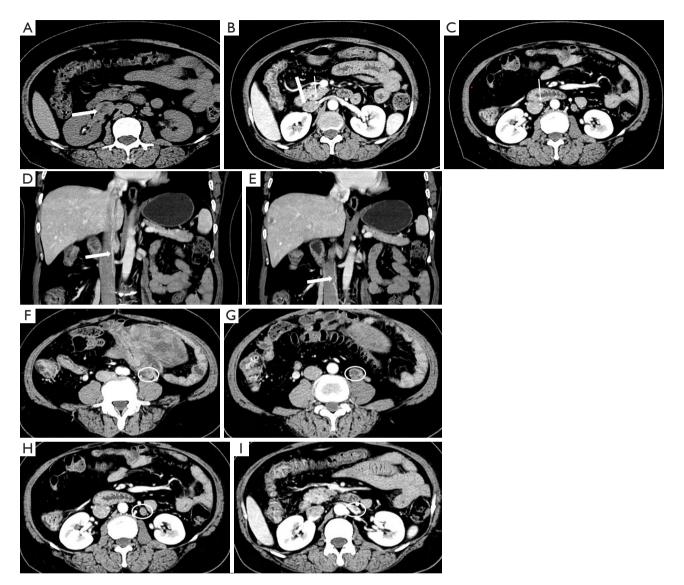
CT images. (A) The arrow points to a low-density occupying lesion within the IVC containing fat density. (B,C) Arterial phase of CT transverse section, thick arrow: IVC filling defect; thin arrow: small vessel visualization. (D,E) CT coronary artery phase, small vessel visualization. The arrow points to a small vessel visualization. (F-I) CT cross-sectional arterial phase of a pelvic venous filling defect extending upward from the vicinity of the pelvic mass to the left renal vein; the picture sequence is caudal to cranial of the patient. The filling defect of the pelvic vein indicated by the circle. CT, computed tomography; IVC, inferior vena cava.
